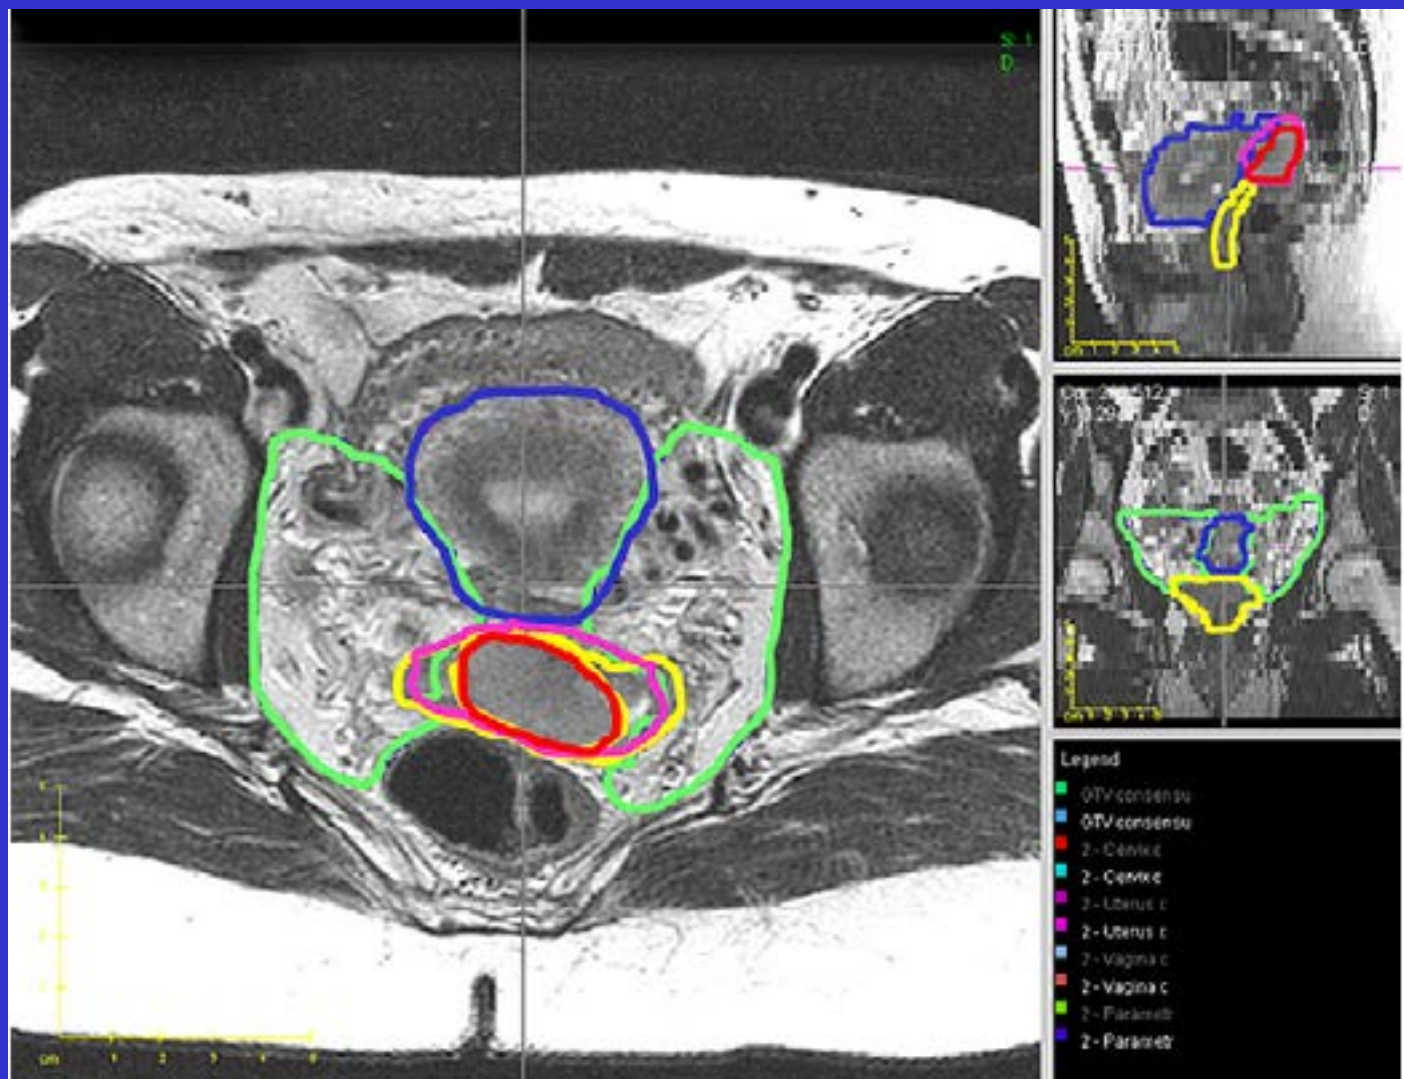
Axial and reconstructed sagittal and coronal views of T<sub>2</sub>-weighted MR images from a clinical contouring case showing 95% agreement contours for GTV (red), cervix (pink), vagina (yellow), parametria (green), and uterus (blue).
